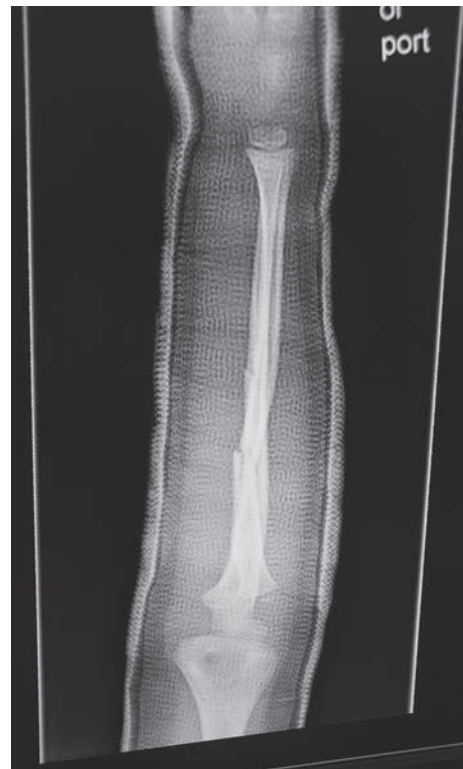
Radiographs obtained in the OR demonstrate excellent reduction and a well-fitting cast. (Property of UW Pediatric Orthopaedics.)
